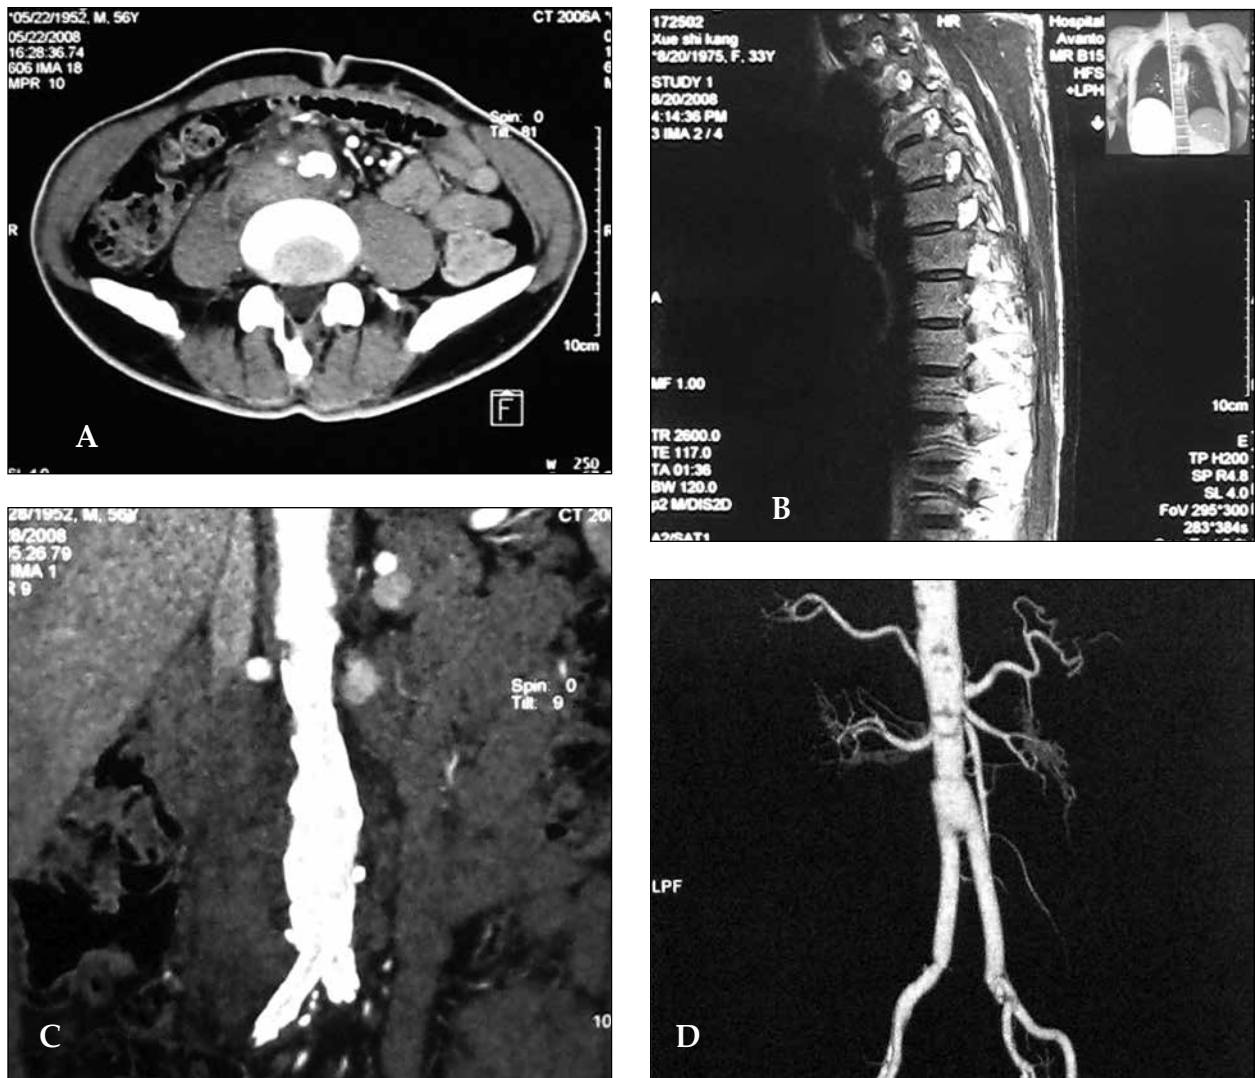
Tuberculous false aneurysm of infrarenal abdominal aorta after endovascular repair for abdominal aortic dissection in a 56-year-old male. (a) The enhanced CT scan showed a huge heterogeneous enhanced mass about 25 x 20 cm in size in the right lower quadrant. (b) Magnetic resonance imaging showed a neighboring paraspinal abscess. (c) CT angiography showing a saccular false aneurysm of the infrarenal aorta without involving the bilateral iliac arteries. (d) Postoperative CT angiography demonstrated the continuity of the abdominal aorta.
